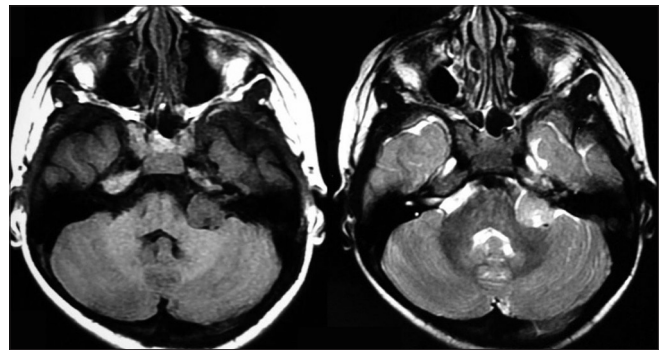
MRI of the brain showed the CP angle lesion which was hypointense on T1W and hyperintense on T2W image
